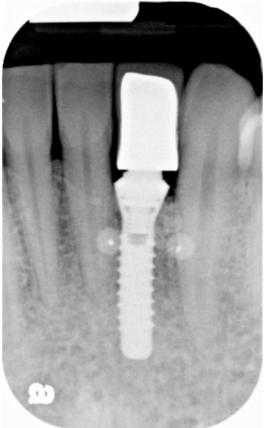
This restoration was cemented onto the abutment. No pre-cementation radiograph was made; the crown did not seat as intended. It is likely the adjacent teeth contacted the restoration prematurely, preventing its placement. The restoring dentist failed to detect this error
